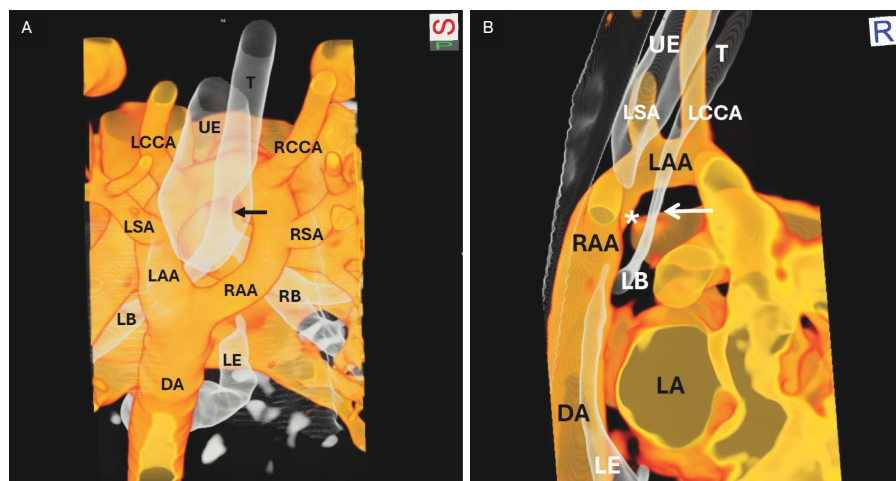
Chest CT with contrast dynamic airway assessment coronal projection. There is distal tracheal narrowing (arrow) at the level of the double aortic arch.
